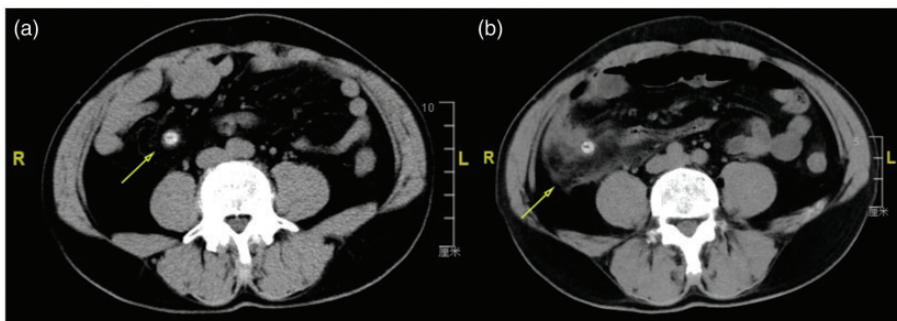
The emergency computed tomography (CT) images. (a) The first image shows that the appendix is slightly thickened and a fecalith is visible in the lumen of the appendix, with some effusion (yellow arrow) and (b) The second scan, obtained 12 hours later, demonstrates substantial effusion around the appendix (yellow arrow).
